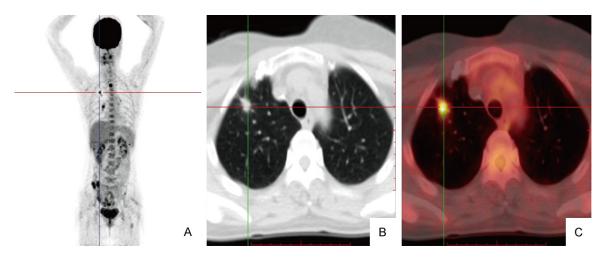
The imaging manifestation of the lung lesion. A nodule with increased fluorodeoxyglucose (FDG) uptake was demonstrated in the right lung on PET imaging (A), the average standard uptake value (SUV) was 6.7. Axial slice of CT (B) showed that the nodule characteristic of multiple spiculations was located in the subpleural area of the apical segment of the upper lobe, approximately 15 mm × 10 mm in size. Fused PET-CT (C) displayed CT and PET features of nodule simultaneously.
